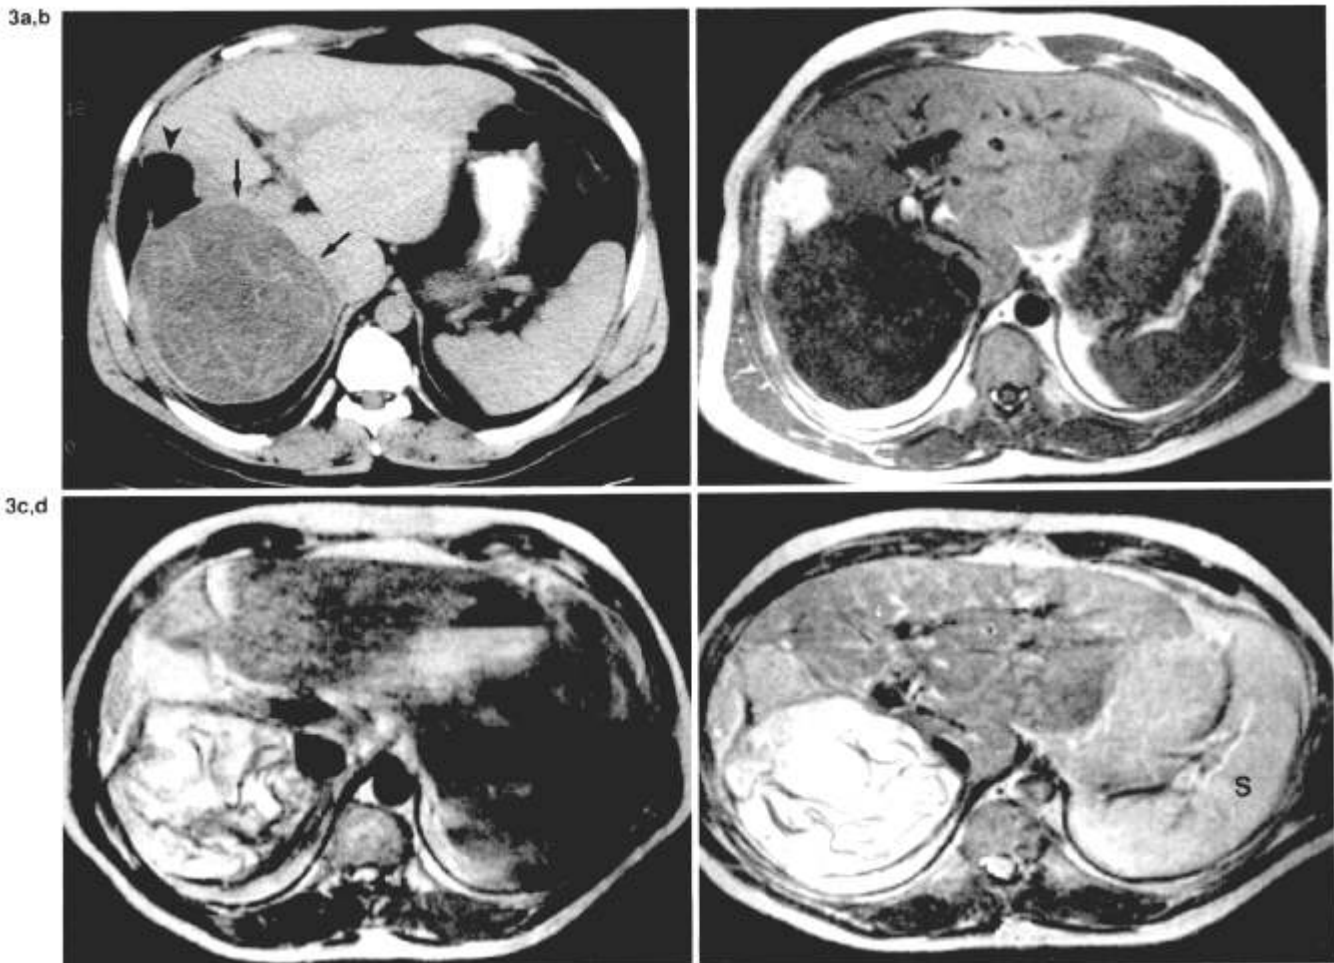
a: CT of treated hydatid cyst of the liver (arrows). Collapsed appearance is probably the effects of 9 months of antihelminthic therapy. There had been previous surgical intervention (arrowhead). b: T1-weighted (TR 600/TE 26) SE image at same level. c: A standard T2-weighted (TR 1,800/TE 100) SE sequence demonstrates the extensive artifacts and signal loss typically associated with long TR images in upper abdomen. d: Motion artifact suppression technique (MAST) image (TR 1,800/TE 100) at the same level, acquired in the same amount of time as (c). Note improved detail within cystic lesion and within spleen (S). This detail is absent on the routine T2-weighted sequence. Portal branches are also well visualized.
